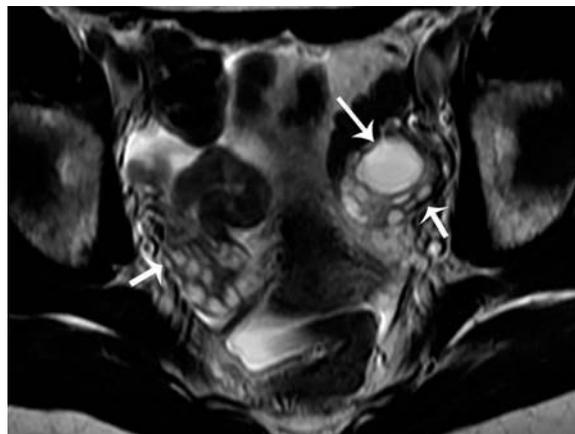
Ovarian follicle in a 37-year-old female. Axial T2-weighted image demonstrates normal bilateral ovaries (short arrows) with a high T2 signal intensity, 2.5 cm, dominant follicle in the left ovary (long arrow).
